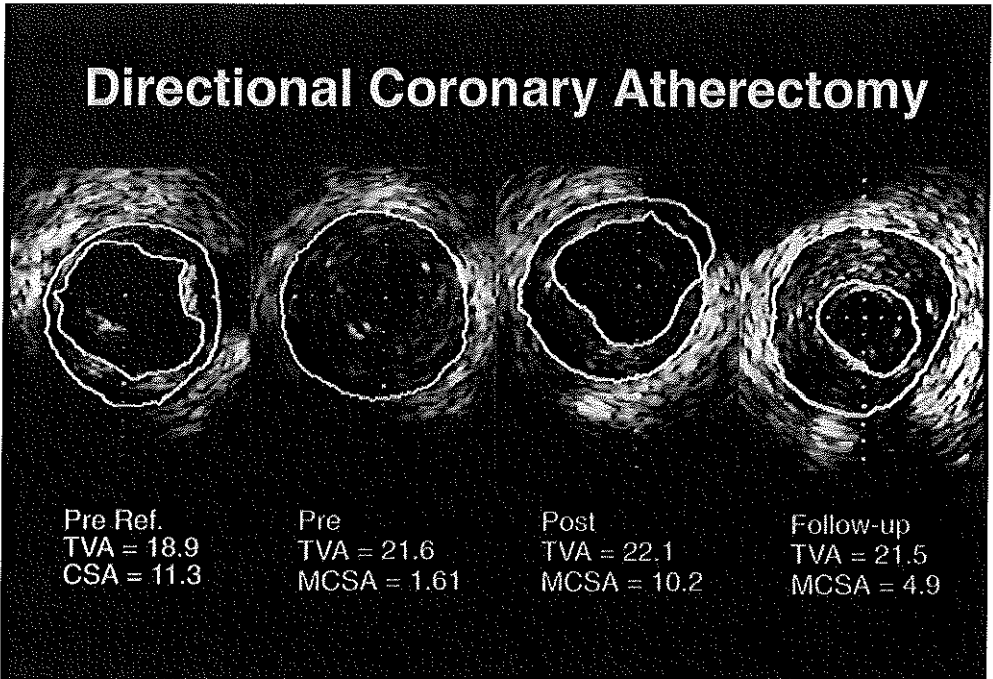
Intracoronary ultrasound (ICUS) images obtained from a patient with compensatory enlargement and treated with directional coronary atherectomy (DCA). Reference segment showed total vessel area (TVA) was 18.9 mm² [extreme left panel]. Pre DCA TVA was 21.6 mm² and minimal cross sectional area (MCSA) was 1.61 mm² [middle left panel]. The ratio of the total vessel area (TVA) at MCSA divided by TVA at the reference site pre intervention (TVA ratio) was 1.14 hence the de novo remodeling mode was one of compensatory enlargement. Post DCA MCSA improved to 10.2 mm² associated with TVA enlargement from 21.6 mm² to 22.1 mm² [middle right panel]. At follow-up MCSA decreased from 10.2 mm² to 4.9 mm² associated with TVA shrinkage from 22.1 mm² to 21.5 mm². In this case 89% of luminal loss was derived from intimal hyperplasia and 11% from late chronic recoil (vessel remodeling) [extreme right panel].
